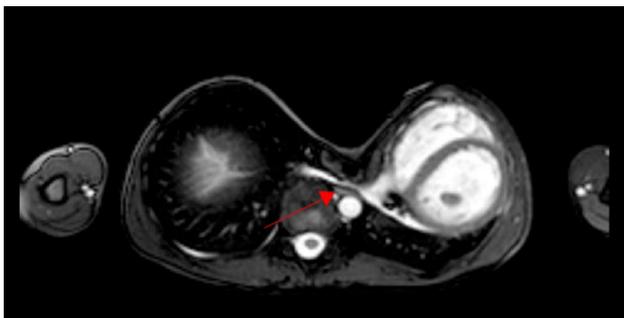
Preoperatively visible constriction of the inferior vena cava; CT transversal image
